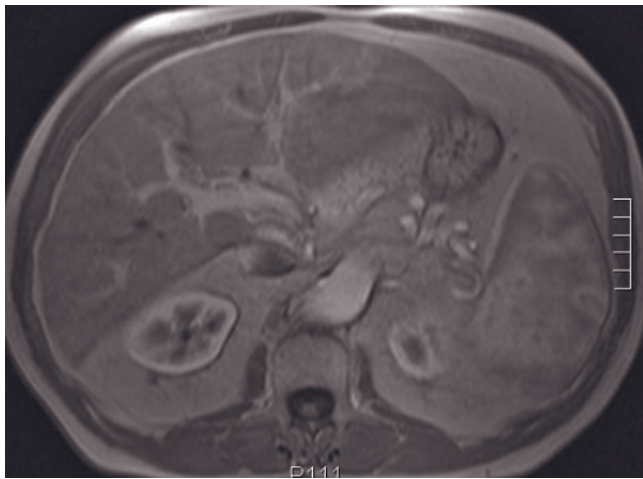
Normal liver and sequences. T2-weighted fat-suppressed SS-ETSE (a), SGE (b), and immediate (c), 45-s (d), and 90-s fat-suppressed (e) postgadolinium SGE images. Liver is lower in signal than normal, non-iron-deposited spleen on the T2-weighted (a) and higher in signal intensity than spleen on the T1-weighted (b) images. A liver imaging protocol should include noncontrast T2-weighted (a) and T1-weighted (b) sequences and hepatic arterial dominant phase (c), early hepatic venous phase (d), and hepatic venous phase fat-suppressed (e) sequences.
